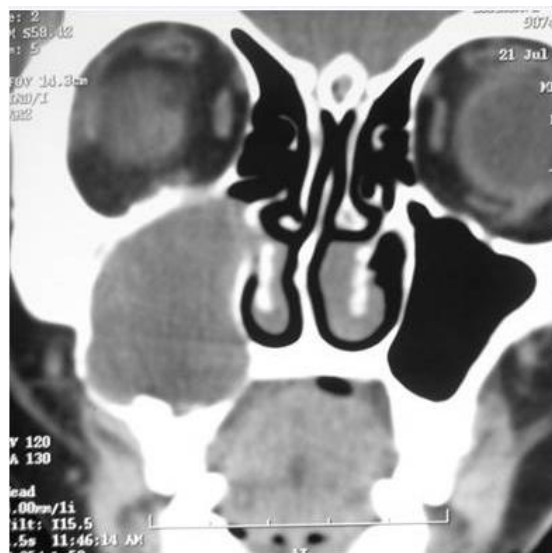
Computed Tomography scan showed lesion was involving right maxillary sinus with the expansion of sinus and inferiorly invading the hard palate, superiorly eroding the orbital floor and medially nearing the nasal septum
